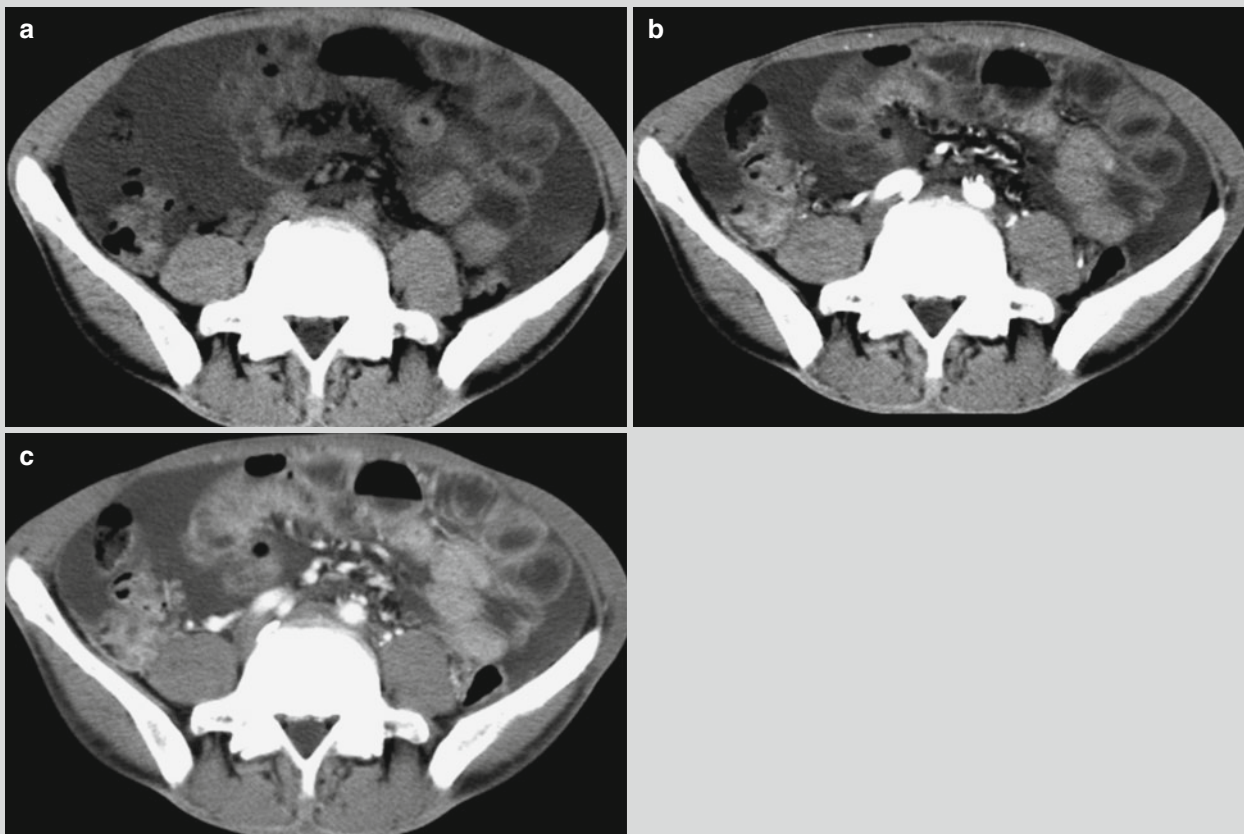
Intestinal malaria and ascites. (a–c) CT scanning demonstrates swelling of the intestinal wall and the colon wall. Contrast CT scanning demonstrates no abnormal enhancement. There are also liquid density shadows surrounding the intestinal canal
